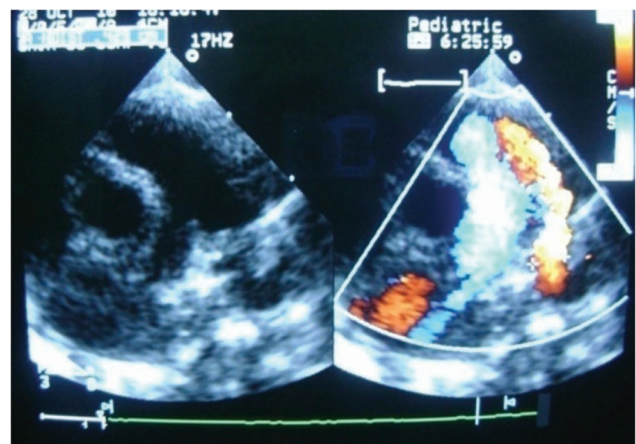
PDA as seen in 2D echo/colour Doppler
